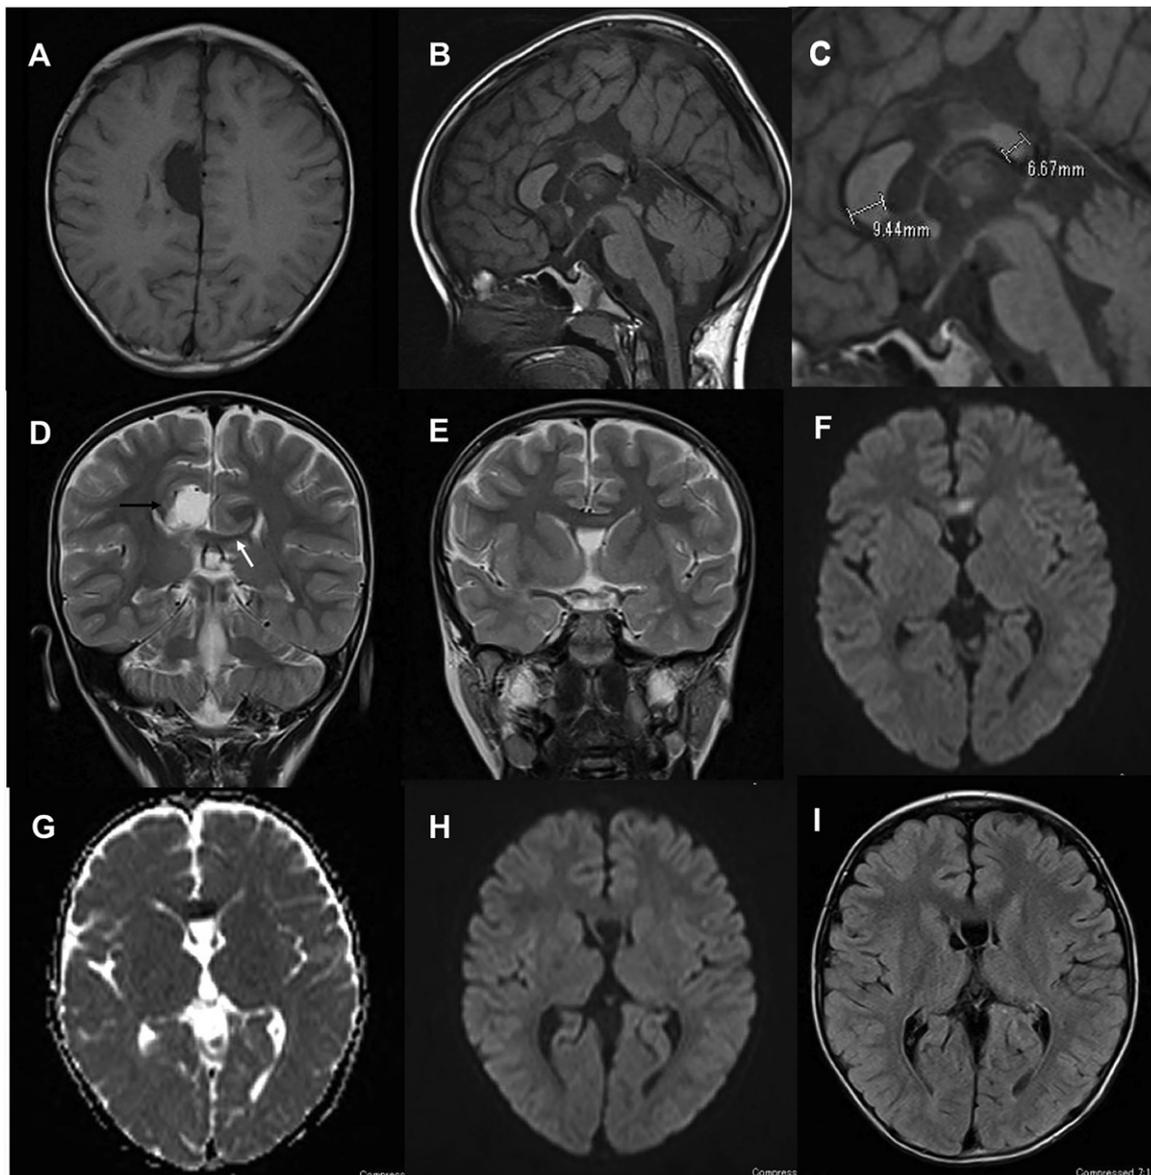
Brain MRI findings. Axial T1-weighted (A) scan shows right interhemispheric cyst adjacent to the falx cerebri. Sagittal T1-weighted scan (B) shows callosal hypogenesis with a nearly absent razor-thin body and hypoplastic splenium, compared to a relatively normally sized genu. Thickness of the genu and splenium were measured as shown in the enlarged figure (C). Coronal T2-weighted scans at the splenium level (D) and genu level (E) show thinning of the axonal fiber of the splenium (white arrow). The interhemispheric cyst is indicated by the black arrow. Significant signal hyperintensity on DWI (F) and hypointensity on ADC (G) was observed in the genu at admission. The hyperintensity signal on DWI of the isolated genu lesion disappeared on day 7 (H). No lesion was noted on corresponding axial T2-FLAIR scan (I).
